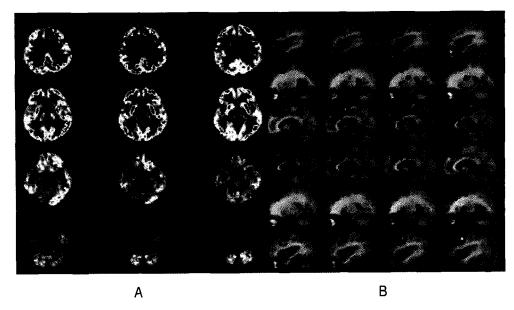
Seventy-four years old male with progressive supranuclear palsy. Axial image of F-18 FDG PET and SPM results comparing with age matched normal controls show significant hypometabolism of midbrain, bilateral medial frontal cortices, caudate nuclei, and thalami.
